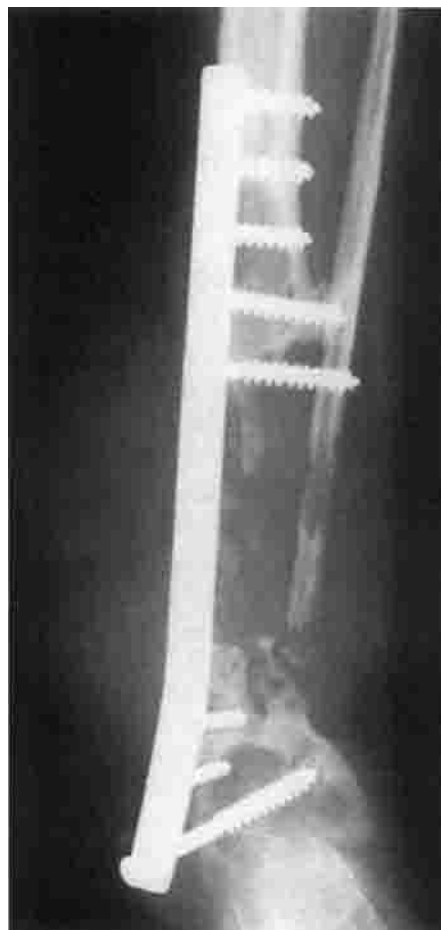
Radiograph of the lower left limb showing a massive tumor largely destroying bony structures. Prosthetic material dates from an operation performed 3 years earlier.
